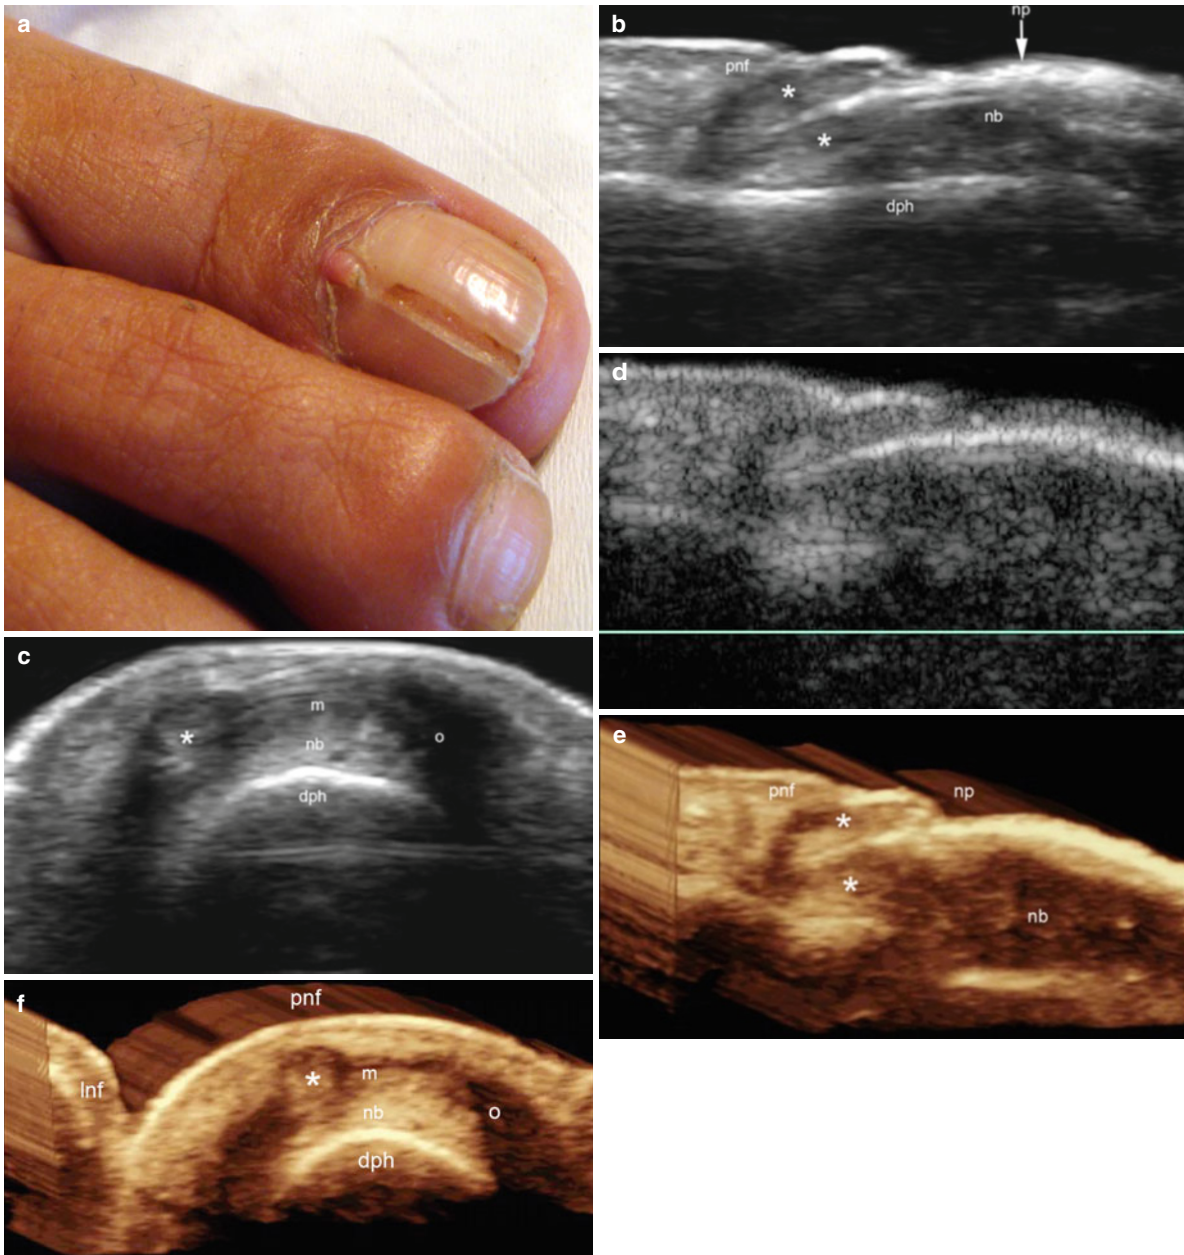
(a–f) Periungual fibrokeratoma. (a) Clinical image shows an erythematous, elongated and polypoid lesion attached to the proximal nail fold. A longitudinal groove is also seen in the nail plate following the same axis of the lesion. (b, c) Grey scale ultrasound images (b longitudinal view; c transverse view) show a polypoid hypoechoic solid structure (*) over the proximal part of the nail plates that also bulges
